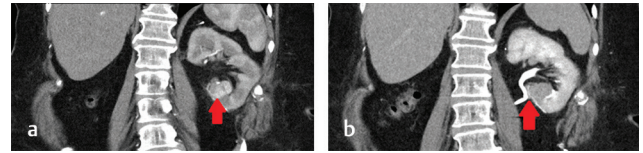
(a) Arterial phase CT with coronal reformats at 6-month surveillance demonstrated 23 × 26 × 22 mm focus of tumor recurrence at the medial margin of the kidney (arrow). (b) Delayed phase CT with coronal reformats shows the ureter deviated laterally (arrow), directly in contact with the partial nephrectomy site. Contrast wash-out also noted within the adjacent tumor.
